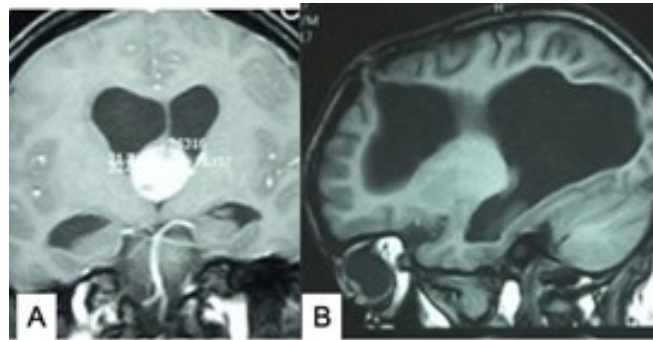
(A) MRI shows chronic HCP with diverticulum. (B) MRI shows colloid cyst of the 3rd ventricle with biventricular HCP. Source: Figure by authors.
